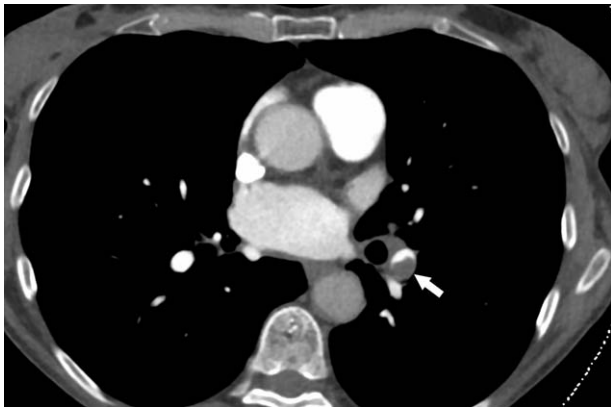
Axial contrast-enhanced CT (arterial phase) at the level of the pulmonary hili shows a filling defect within the left lower pulmonary artery (arrow), consistent with left lobar pulmonary embolism. CT = computed tomography.
